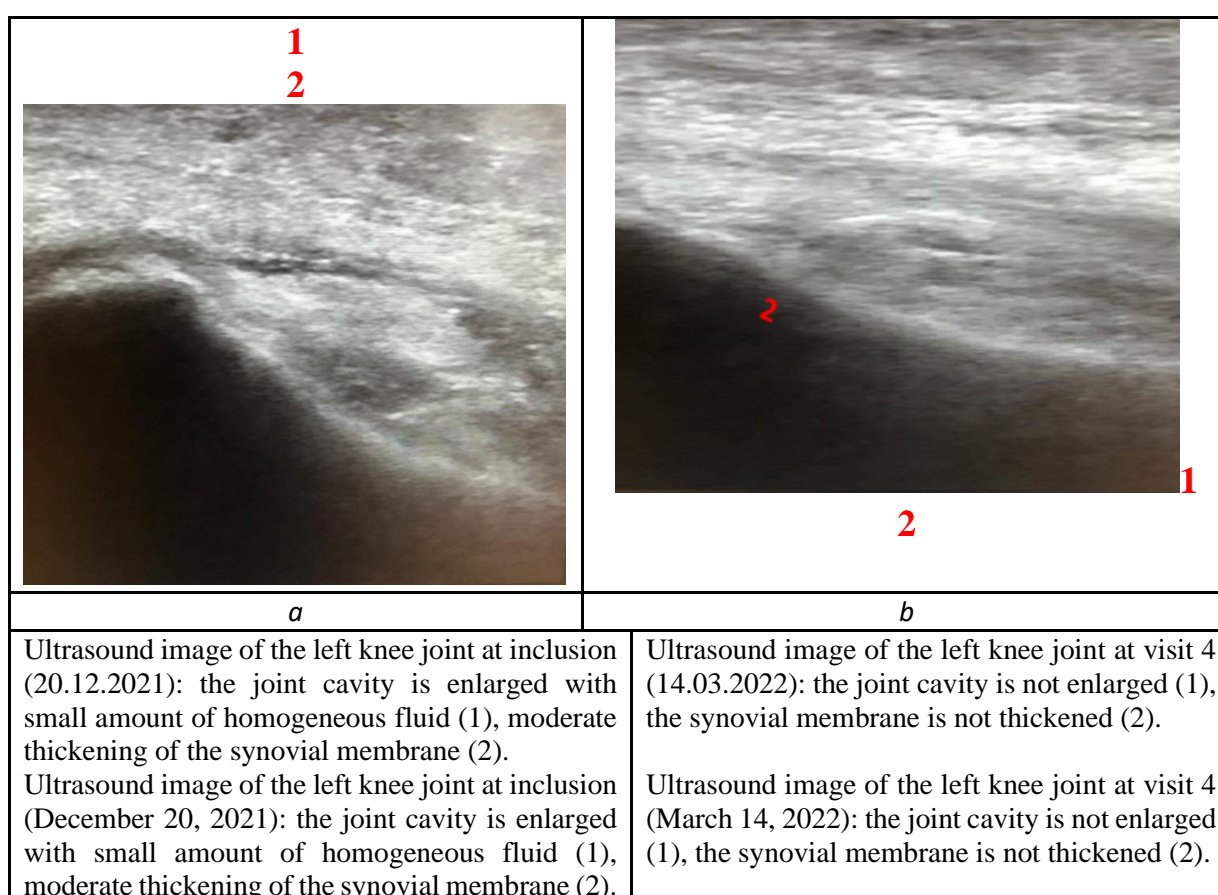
Ultrasound image of the knee joints of patient S., 50 years old, before and after taking dietary supplement Bi-Luron
